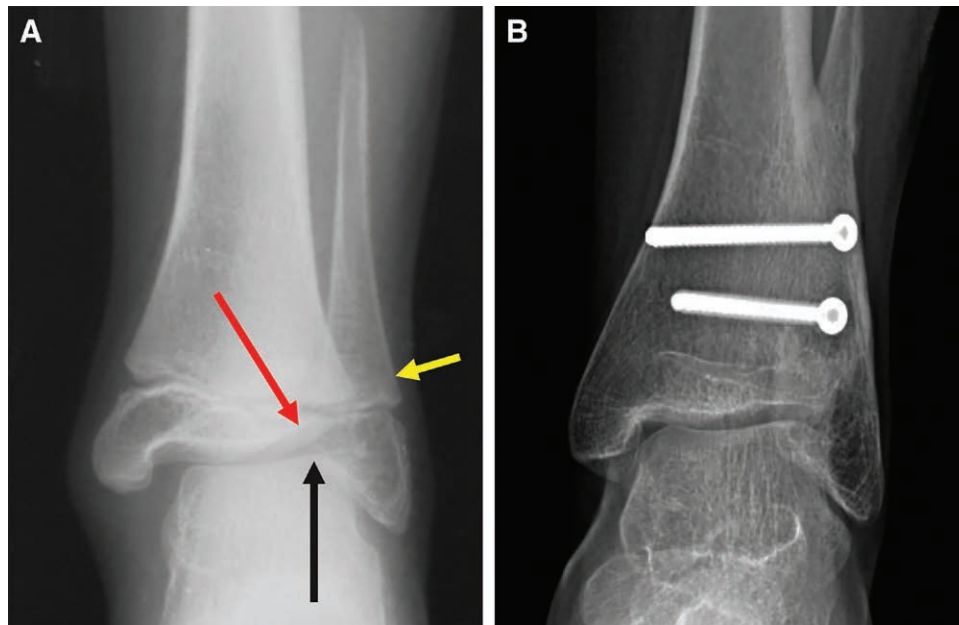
Radiographic features of ankle valgus deformity: proximal fibular migration (yellow arrow), lateral tibial epiphyseal atrophy (red arrow), and talar subluxation (black arrow) (A); tibiotalar stabilization with syndesmotic screw (B).
